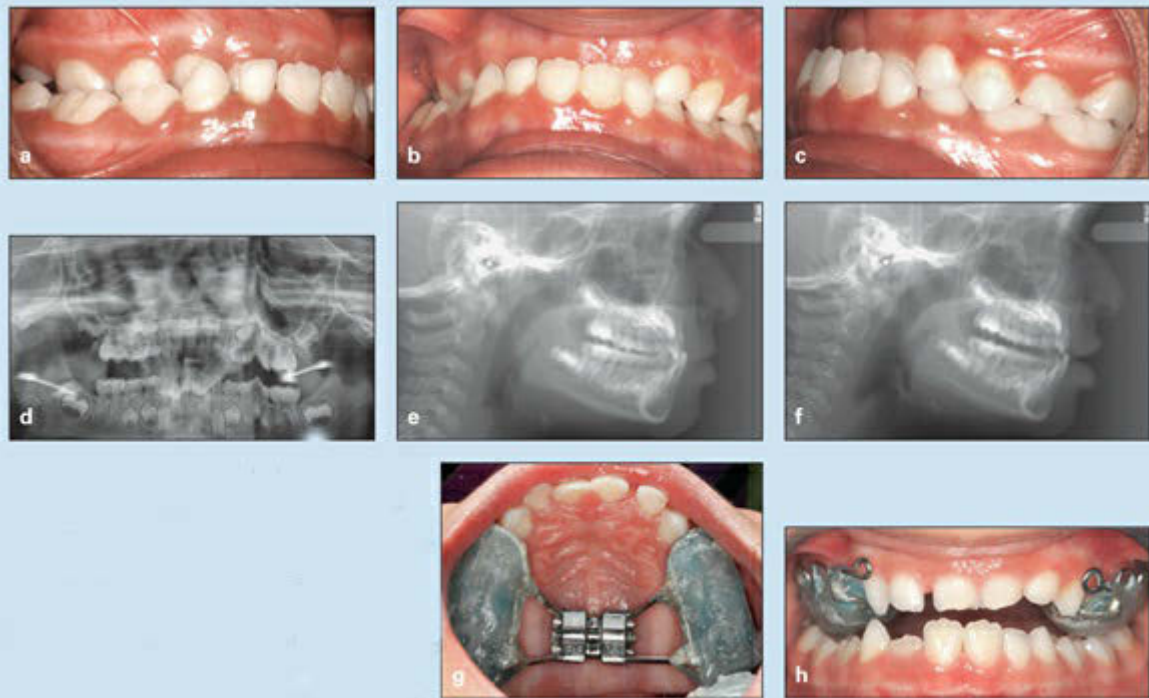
Management of skeletal Class III malocclusion, posterior and anterior crossbites, and mandibular shift in a 6-year, 4-month-old girl. Both maxillary permanent lateral incisors are congenitally missing. (a to c) Pretreatment occlusion. (d) Pretreatment panoramic radiograph. (e) Pretreatment cephalometric radiograph in centric occlusion. (f) Pretreatment cephalometric radiograph in centric relation. (g and h) Bonded rapid expander with hook for mask protraction.
